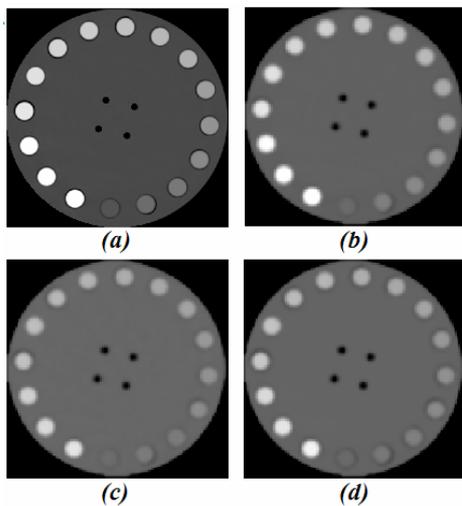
Original CT image (a) and generated attenuation maps using bilinear (b), dual energy (80 and 140 kVps) (c) and virtual dual-energy (d)
